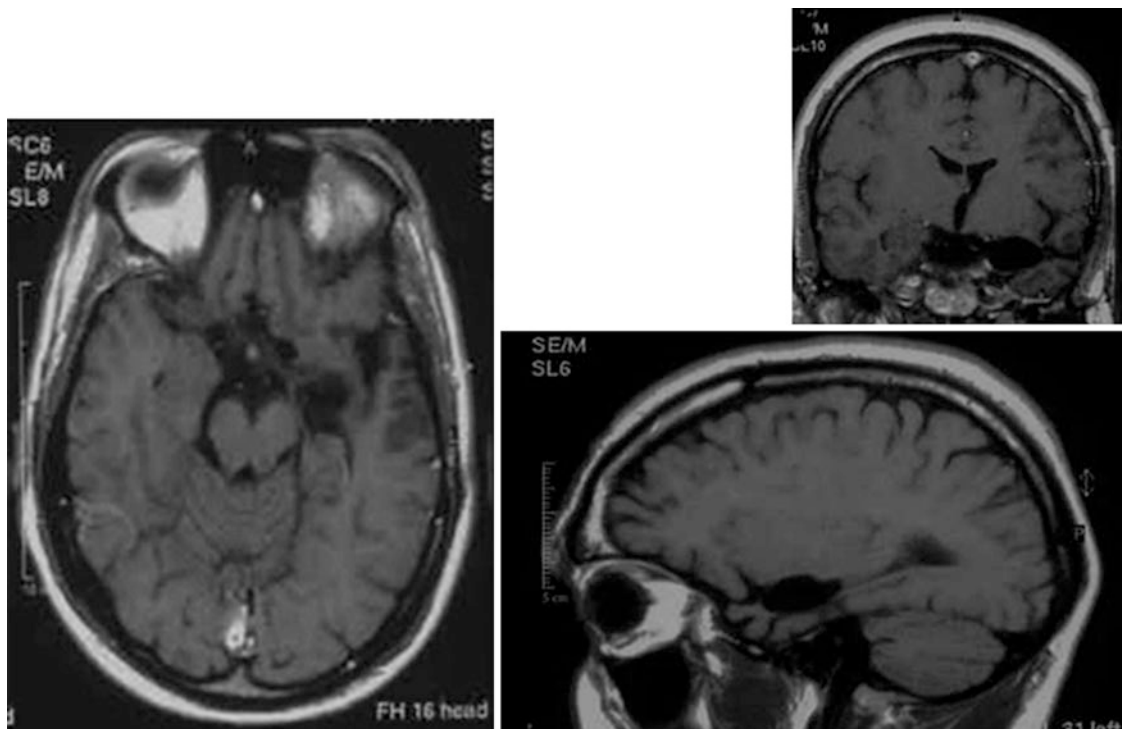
Postoperative MRI after selective amygdalo-hippocampectomy
